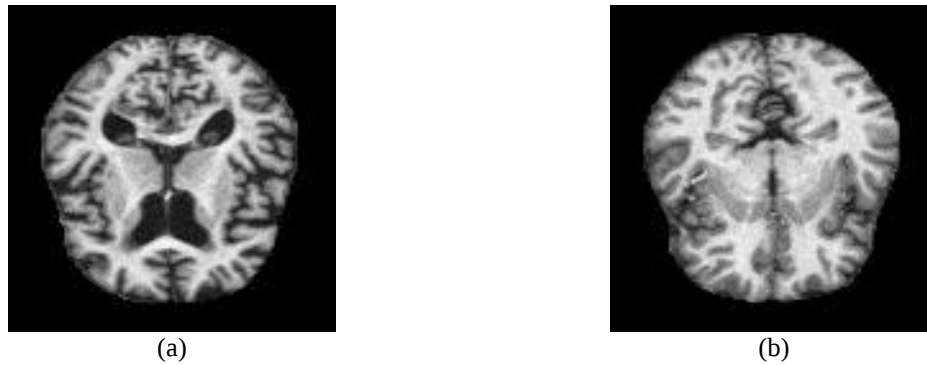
MRI of Alzheimer's brain tissue (a) Mild Impairment (b) No Impairment
